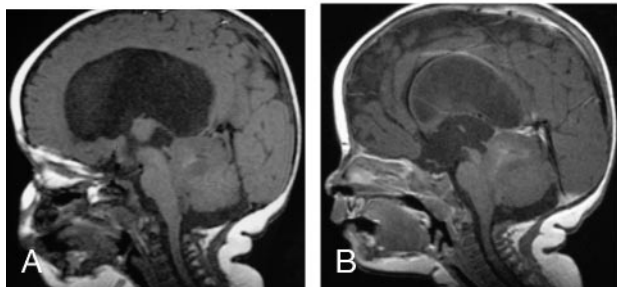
MR images of a 4-month-old female infant with a germ-line mutation of the hSNF5/INI1 gene with synchronous AT/RT, showing contiguous involvement of the pineal gland, dorsal midbrain, and upper cerebellum and a malignant rhabdoid tumor involving the left kidney.
